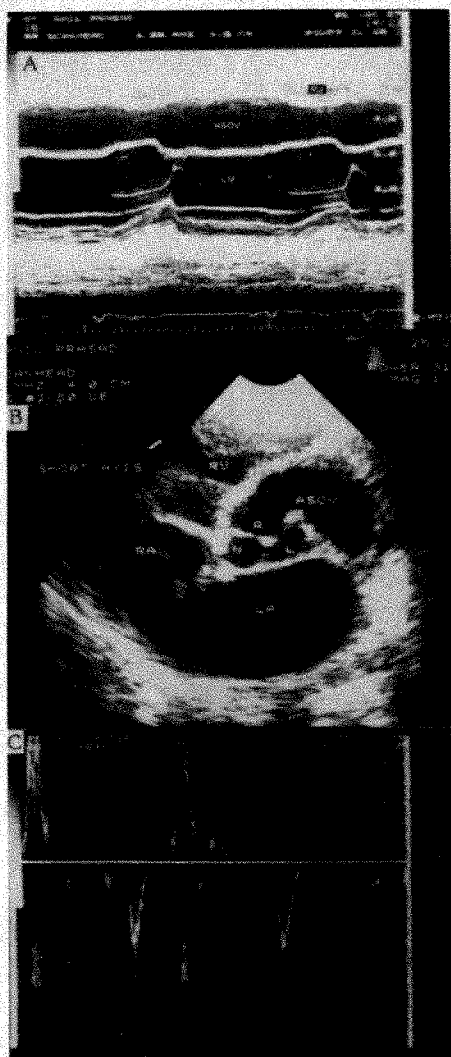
A, M-mode cut at the level of mitral valve showing systolic collapse and the diastolic expansion of the aneurysm in the interventricular septum. B, short-axis view at the level of aortic valve clearly showing communication of the aneurysm with right coronary sinus (R). C, to and fro Doppler signal at site of the communication of aneurysm with right coronary sinus. ASOV = aneurysm of the sinus of Valsalva; L = left coronary sinus; LA = left atrium; N = noncoronary sinus; RA = right atrium; RV = right ventricle.
